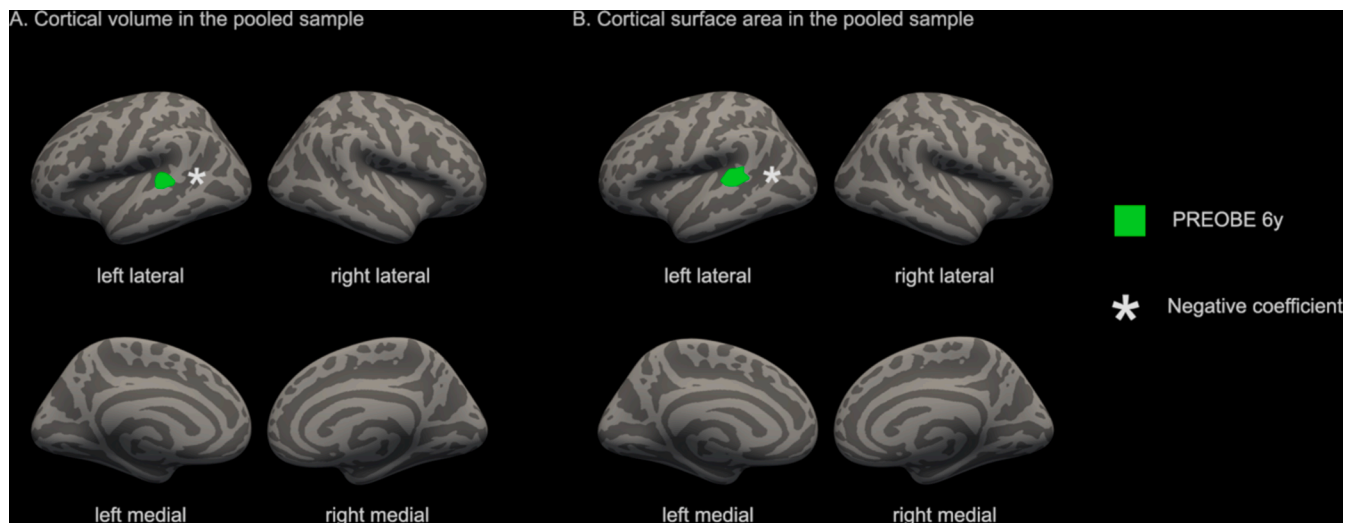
Cortical clusters associated with elevated prenatal maternal CRP (>10 mg/L) in the clinical cohort. Associations between offspring cortical morphology and categorical prenatal maternal CRP (>10 mg/L compared to <3 mg/L) in the clinical cohort PREOBE. Maternal CRP was collected during the second trimester (24 weeks) of pregnancy. The model was adjusted for participant age at MR imaging, gestational week of CRP measurement, maternal smoking, alcohol use, pre-pregnancy BMI, age, and education. Panel A represents cortical volume and panel B represents surface area, the shown clusters are from pooled analysis of both sexes.
